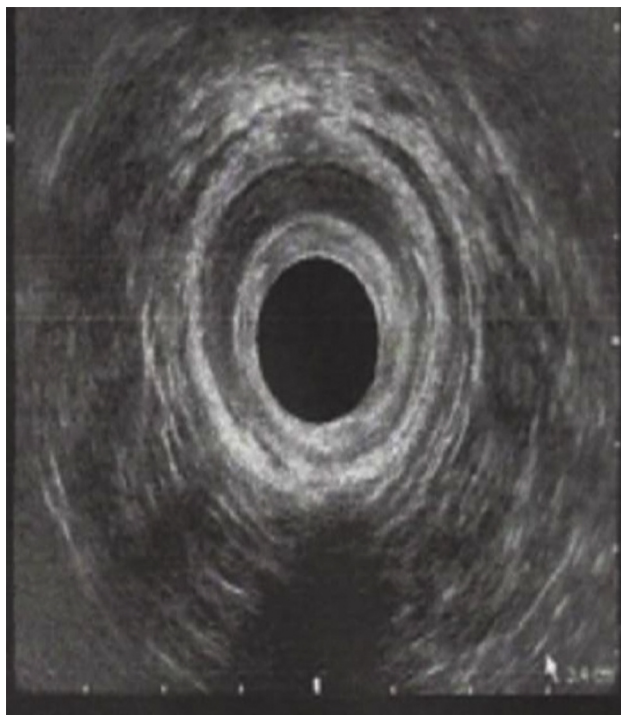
3D endoanal ultrasound showing thinning of the anal canal, without any lesions.
